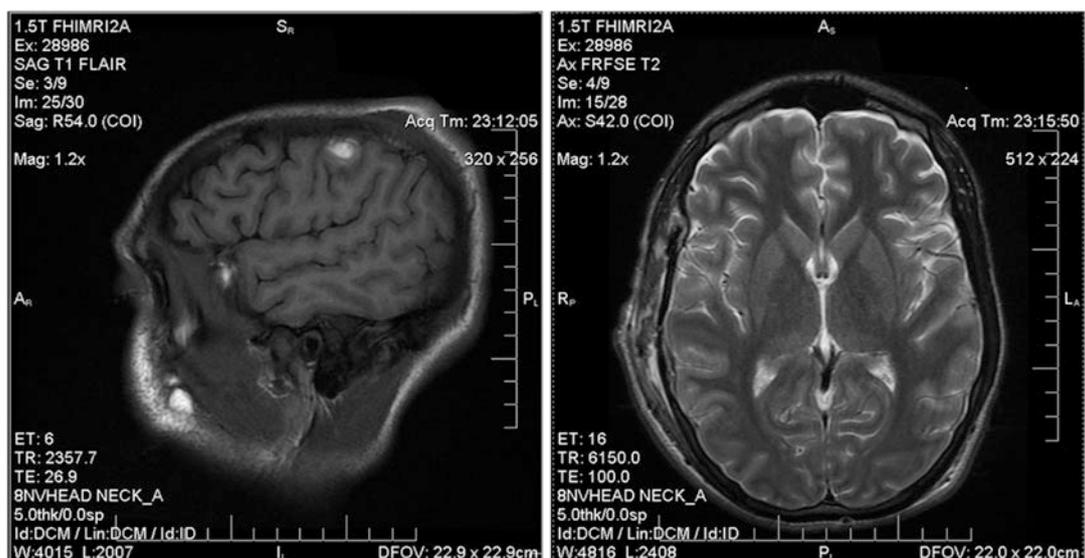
MRI showing diffuse axonal injury damage 10 days after TBI. T2-weighted magnetic resonance imaging (MRI) on hospital day 10. Note the right cerebral convexity subdural hemorrhage, right postcentral gyrus and left temporal lobe parenchymal petechial hemorrhage, and small superior vermian subarachnoid hemorrhage in the image on the *right*. In addition, multiple zones of abnormal fluid-attenuated inversion recovery signals consistent with diffuse axonal injury (DAI) are present on both images (Lewis et al. 2013)
